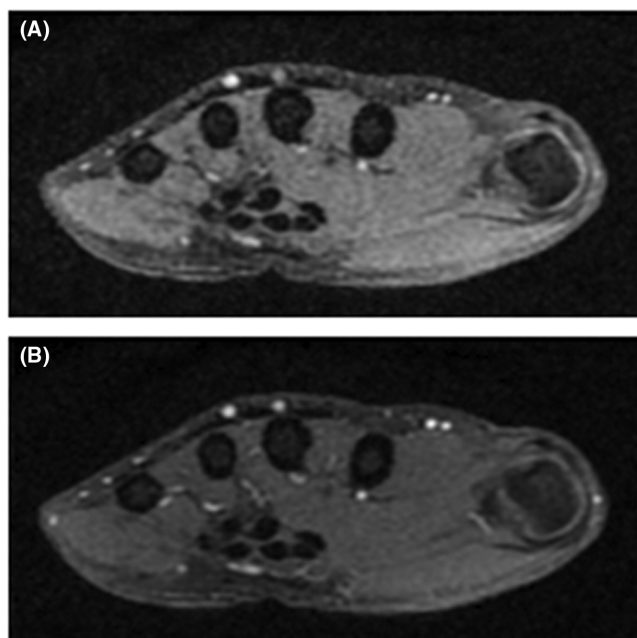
(A) MRI image of the left hand showing full regression of tenosynovitis. (B) MRI image of the left hand showing full regression of tenosynovitis
